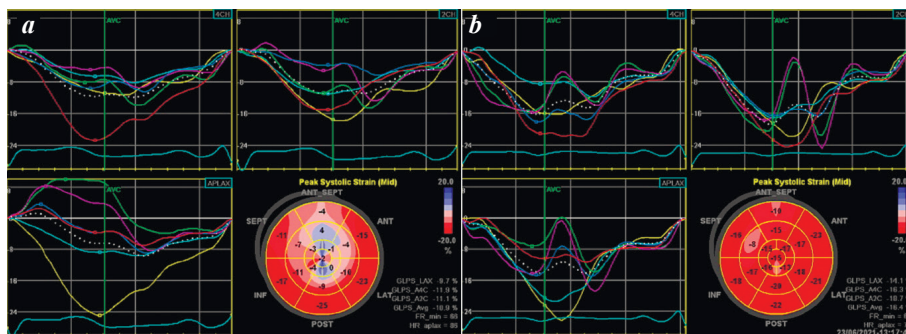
Speckle tracking echocardiography with evaluation of curves and indices of longitudinal myocardial deformation in 17 segments, maximum systolic deformation for each of the 17 LV segments in the form of a «bull's eye»: a - evaluation of indices on the fourth day after PV cryoablation (significant decrease in segmental longitudinal deformation in the LV apex of all its walls, typical for apical TTC, GLPS avg -10.9%); b - in dynamics 1 month after PV cryoablation (a significant decrease in the area of segmental longitudinal deformation in the LV apex is noted, GLPS avg -16.4%). Note: GLPS - Global Longitudinal Strain, LV - left ventricle, PV - pulmonary vein, TTC - takotsubo cardiomyopathy.
